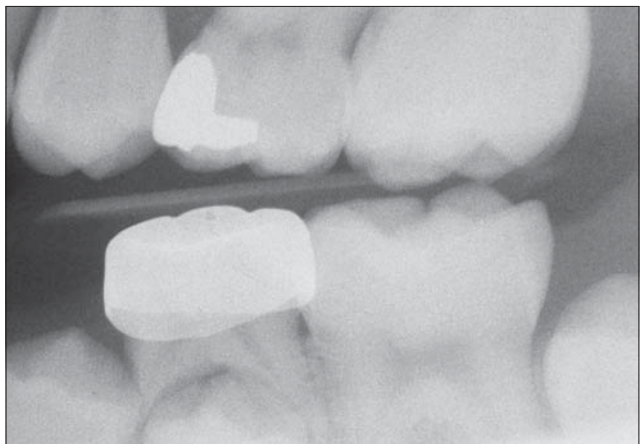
Case B; a 4-year postoperative bitewing radiograph of an IPT with a SSC from 2a of the mandibular left second primary molar.
